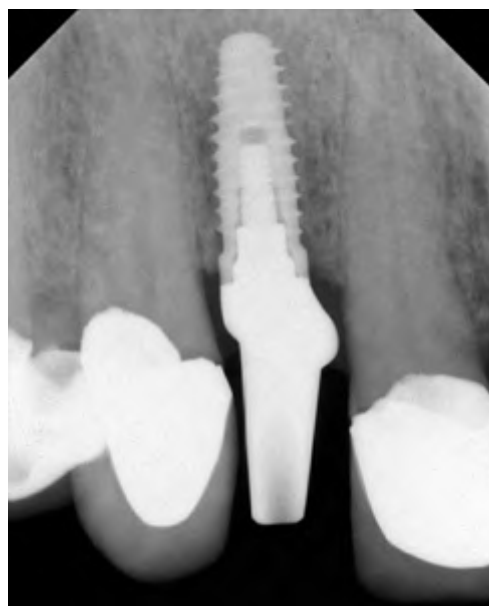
Verification radiograph with the zirconia abutment and try-in screw in place. The abutment was correctly seated into the implant prior to placing any torque on the try-in screw.
